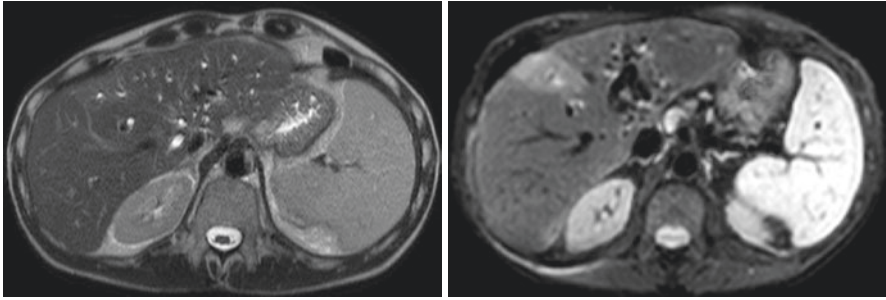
Single Shot TSE T2-weighted images (right) compared with  $b = 10 \text{ s/mm}^2$  SE-EPI DW images (left). On DW images the black blood effect (elimination of vascular signal) increases significantly lesion conspicuity
